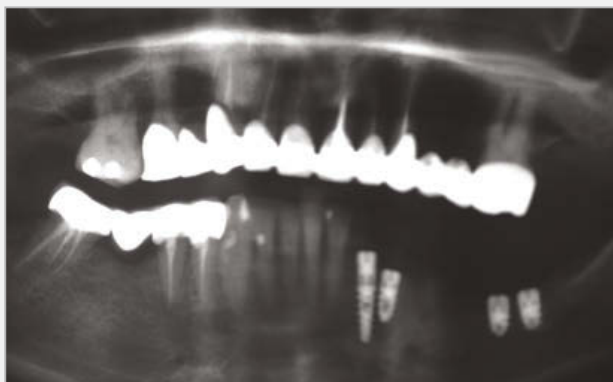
Case 3 - Panoramic x-ray after insertion.
